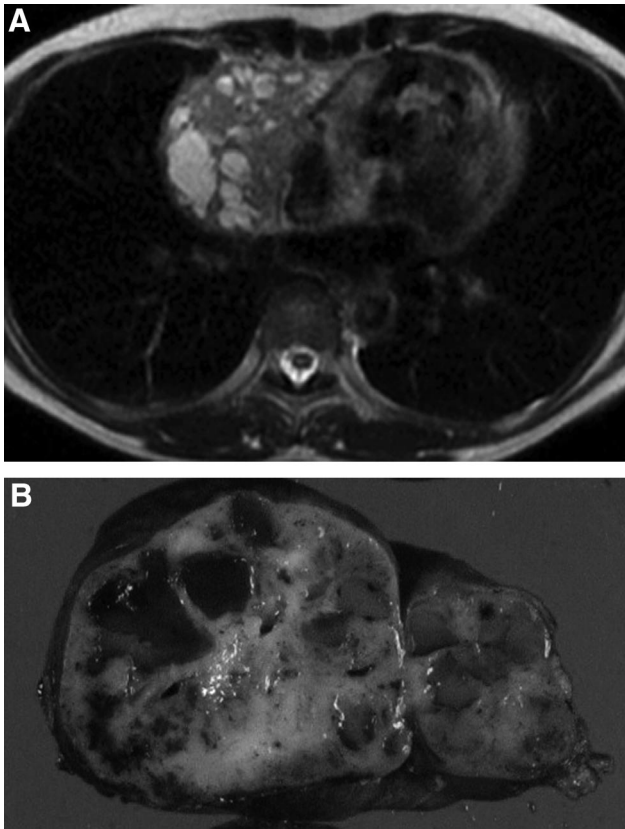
Magnetic resonance imaging (MRI) and gross appearance of mucosa-associated lymphoid tissue (MALT) thymic lymphoma. Case 4:; upper image, transverse T2-weighted MRI showed a multilocular cyst in the right anterior mediastinum. Lower image: the cut surface of the tumor shows multiple follicular cysts.
